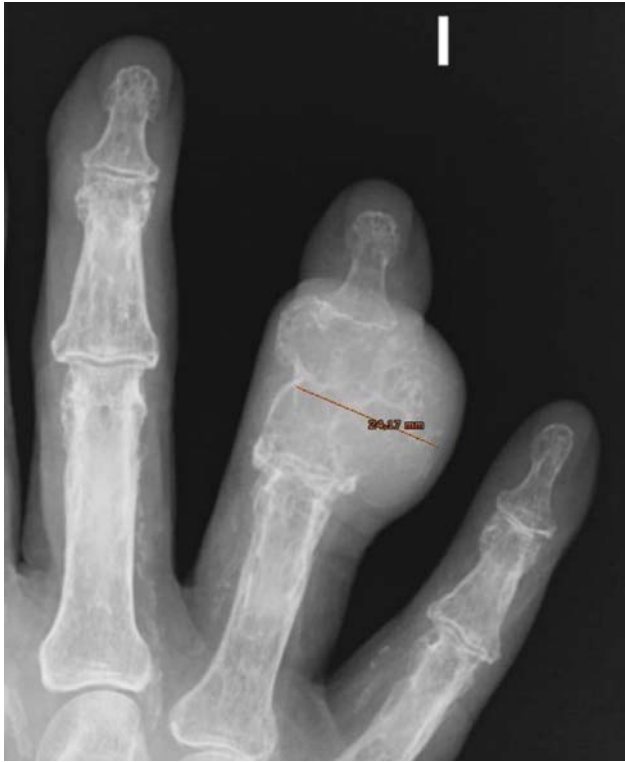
Oblique simple radiography showing an expansive lesion at the middle phalanx of the fourth finger.
